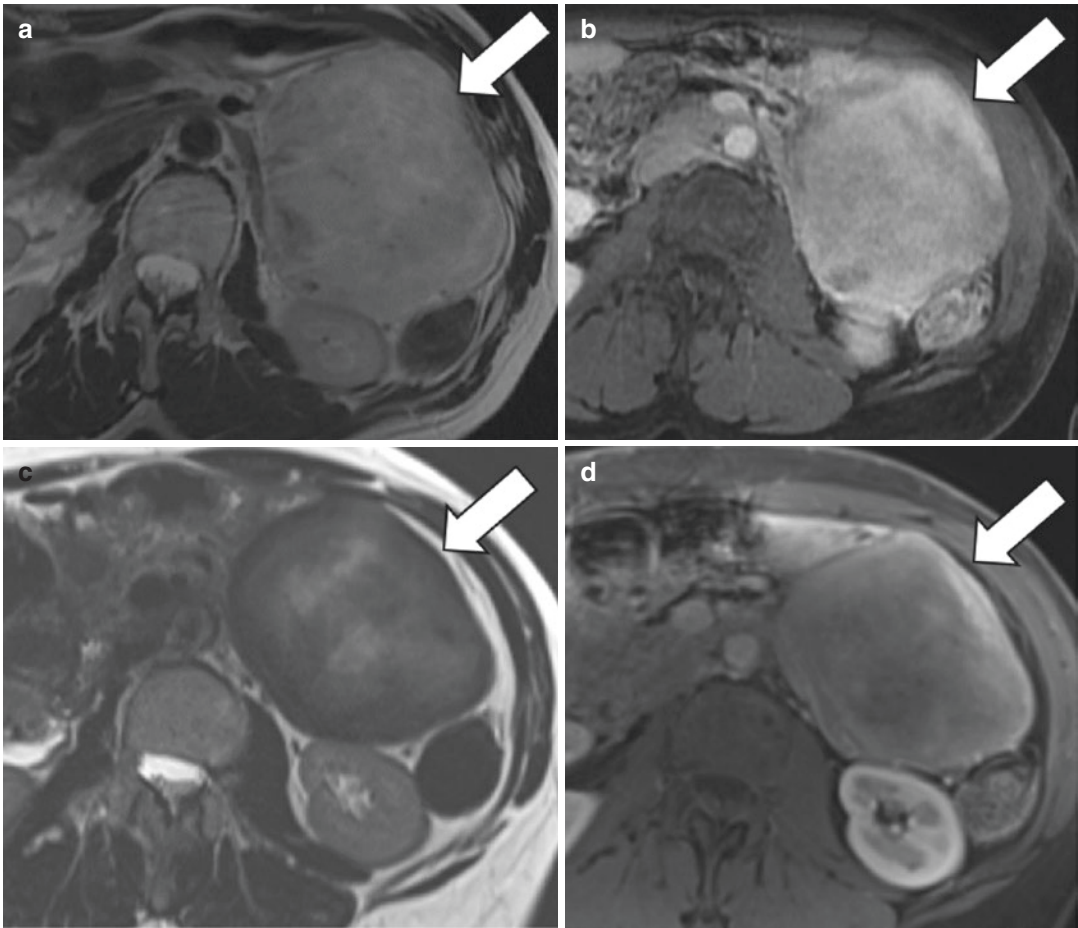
53-year-old woman with mesenteric desmoid tumor treated with systemic therapy. (a, b) Axial T2-weighted and post-gadolinium fat-suppressed T1-weighted MR images demonstrate a well-circumscribed mildly heterogeneous T2 hyperintense mass within the mesentery which shows intense enhancement
